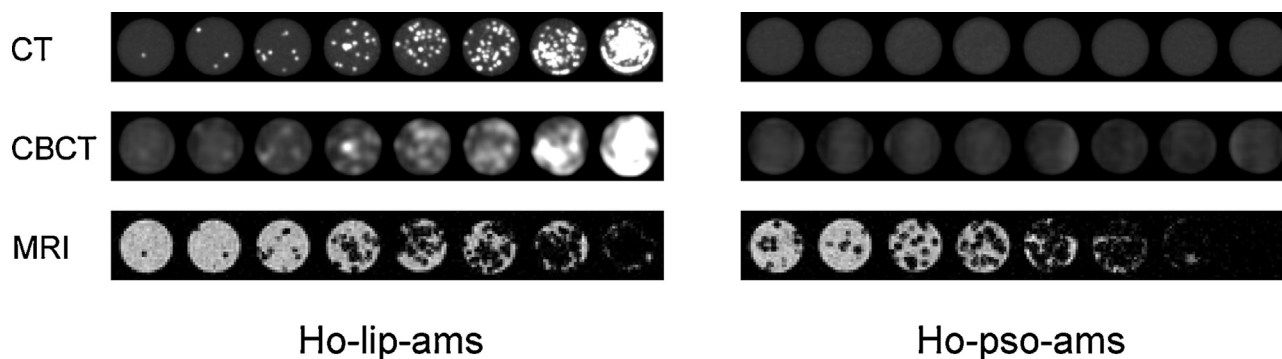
Transverse images of a concentration series of Ho-lip-ams and Ho-pso-ams. The Ho-lip-ams can be depicted as single spheres using multimodality imaging (CT, CBCT and MRI). For Ho-pso-ams, only MRI allows for microsphere visualization due to the absence of radiopaque lipiodol. MR images are taken from the third echo (TE = 14.2 ms).
